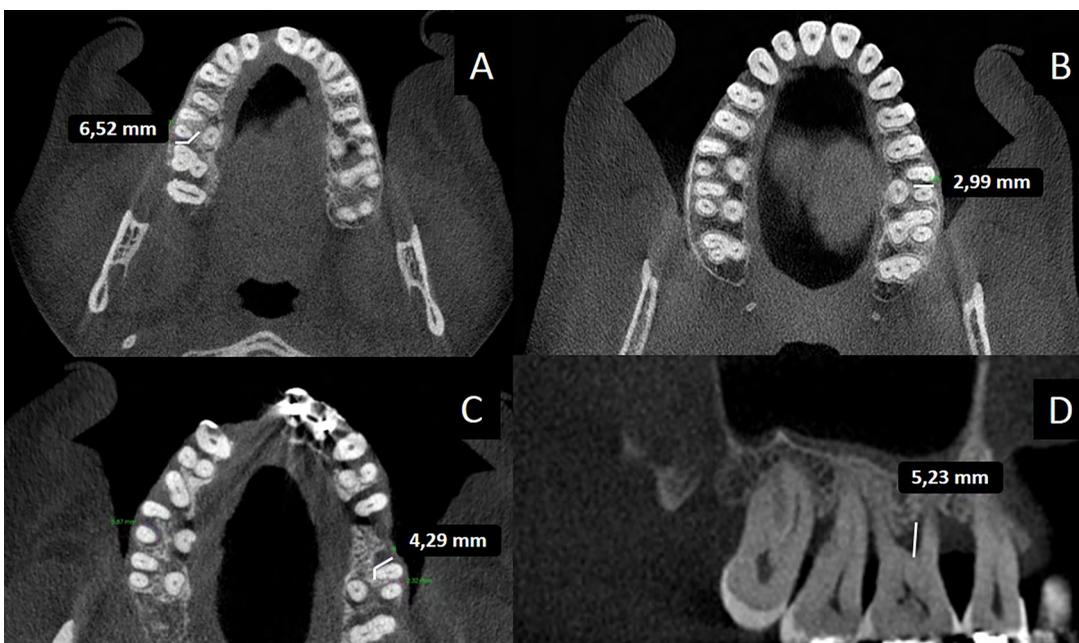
Image of measurements made on CBCT images on software InVivo Dental Application. A) Horizontal measurement at distal site; B) Horizontal measurement at buccal site; C) Horizontal measurement at mesial site; D) Vertical measurement on buccal face.
